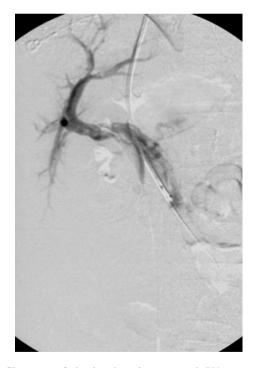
Transjugular transhepatic contrast injection of the SMV after overnight thrombolysis revealed persistent complete portomesenteric thrombosis with retrograde filling of mesenteric collateral veins (*large arrow*) and large gastric varices (*small arrow*). A 0.018-inch wire (*arrowhead*) was initially placed into the thrombosed portomesenteric system percutaneously by ultrasound guidance to serve as a target for transjugular transhepatic access
